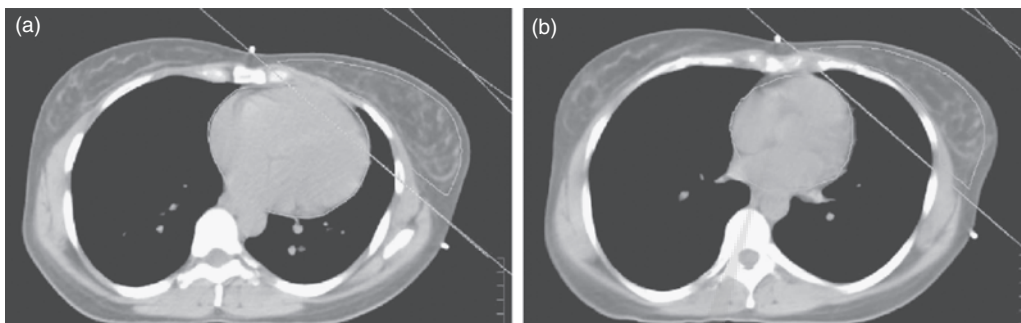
Axial CT images showing the path of the tangential fields in (A) free breathing and (B) DIBH in a patient undergoing treatment for left-sided breast cancer. At deep inspiration, the volume of heart in the RT fields was substantially reduced.
